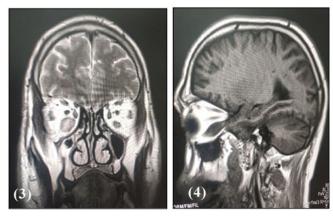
MRI Images of Orbital Pseudotumor
